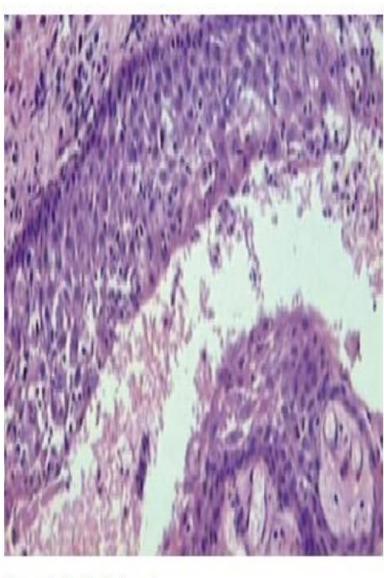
Periapical cyst
